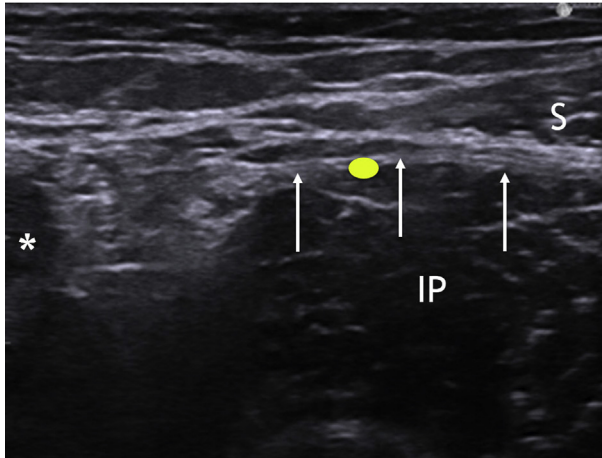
Ultrasound landmarks for infra-inguinal FICB. White asterisk: Femoral artery, White arrows: Iliac fascia, IP: Iliopsoas muscle, S: Sartorius muscle, Yellow dot: needle injection point.
